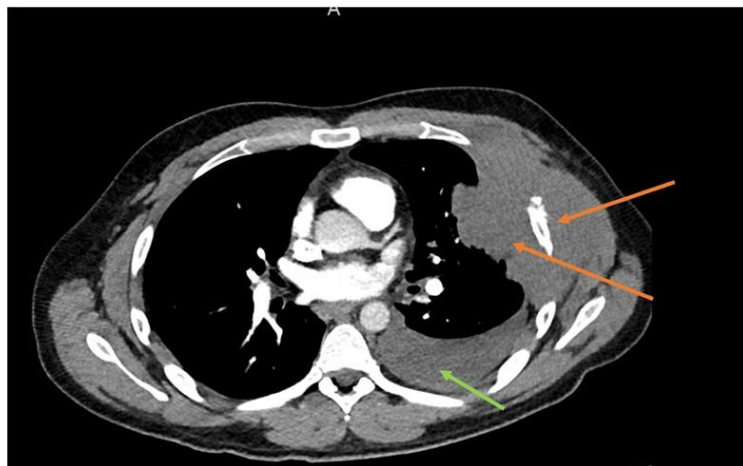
CTA Thorax, with orange arrows indicating a destructive left sided thoracic mass. Green arrow shows moderate left pleural effusion.
